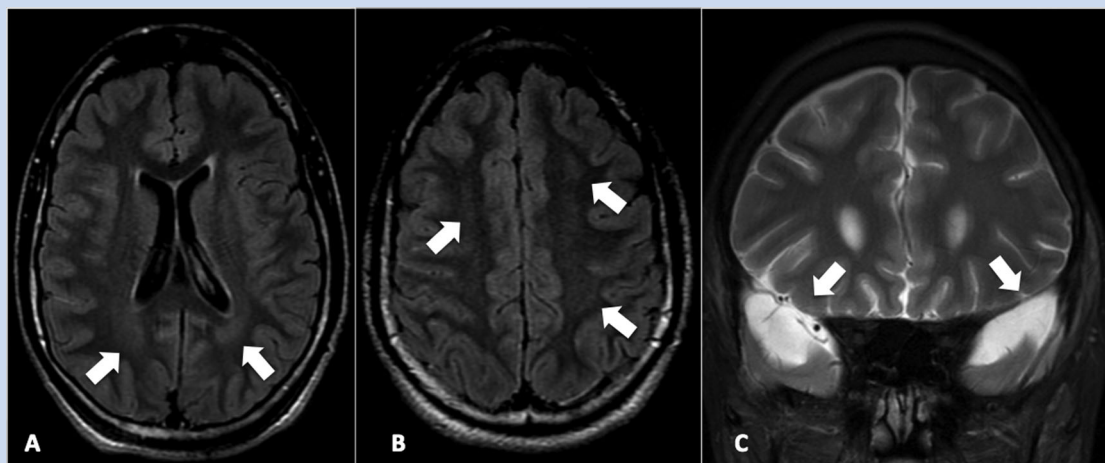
Patient 5—Axial FLAIR with mild nonspecific periventricular (A) and focal subcortical (B) hyperintensities. Patient 6—Coronal T2 WI with bilateral temporal pole arachnoid cysts (C).
